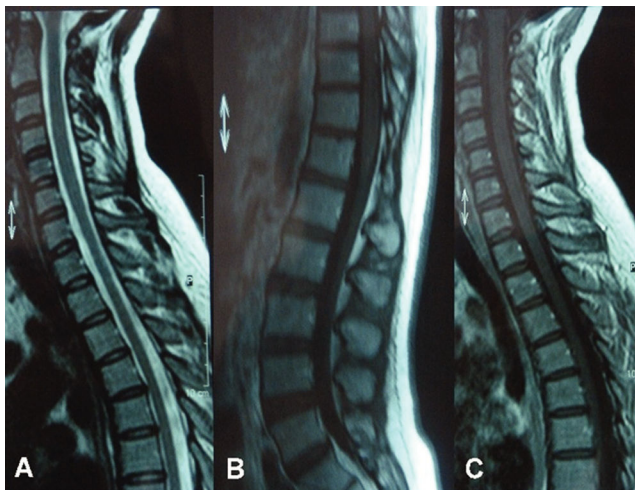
Non-contrast T2-weighted image of the cervical and thoracic spinal cord (a), contrast sagittal T1-weighted image of the conus medullaris (b), and contrast T1-weighted image of the cervical and thoracic spinal cord (c) reveal normal findings
